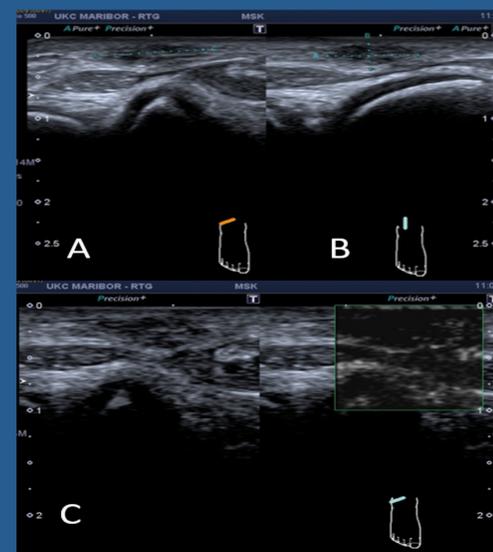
US of the right ankle. Additional subcutaneous mass is demonstrated anterolaterally at the level of the talocrural joint (between blue markers) in the transverse (A) and sagittal plane (B). Again, no vascularity is demonstrated on the Doppler examination (C).
